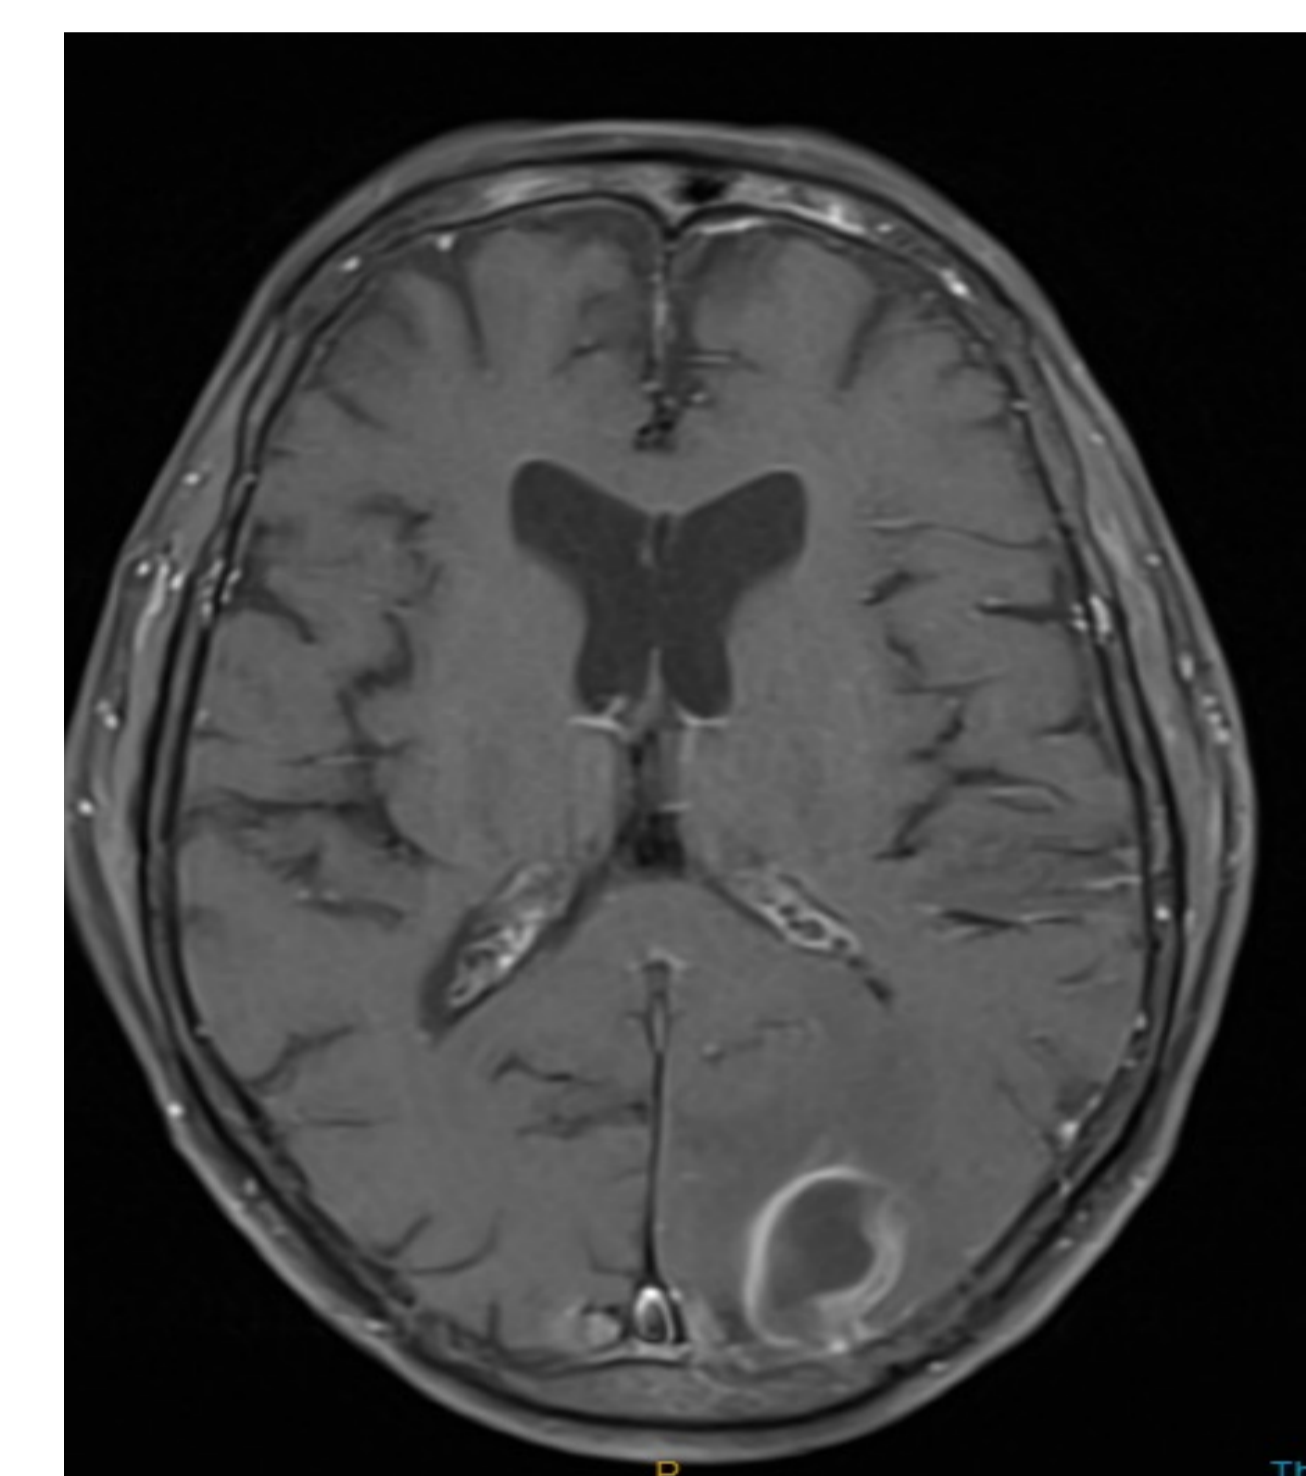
MRI Brain T1 weighted
